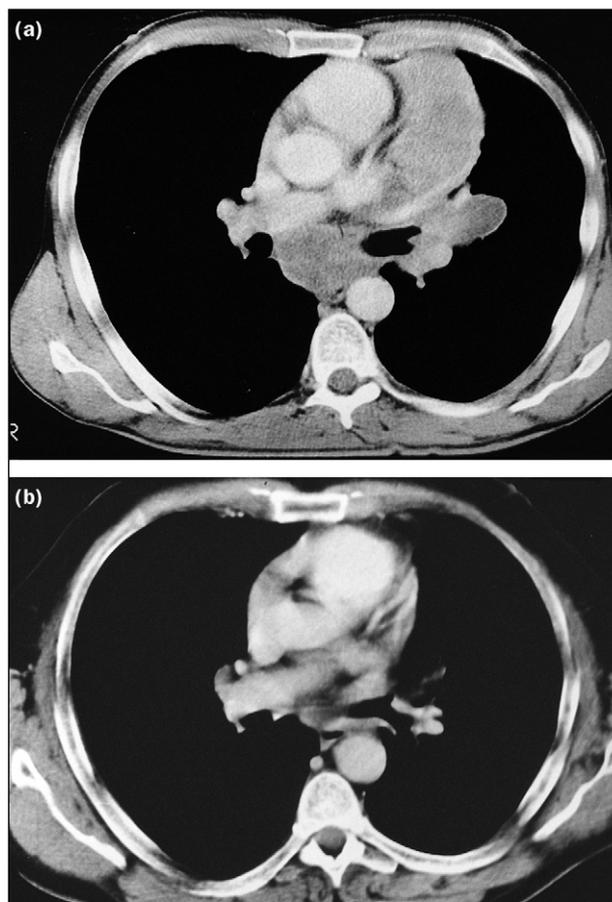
(a) Mid-thoracic CT scan image showing large left para-mediastinal mass, left hilar and carinal lymphadenopathy in a patient with squamous carcinoma in the left main bronchus. (b) Identical slice in the same patient following four cycles of MIC (mitomycin, ifosfamide and cisplatin) chemotherapy.
